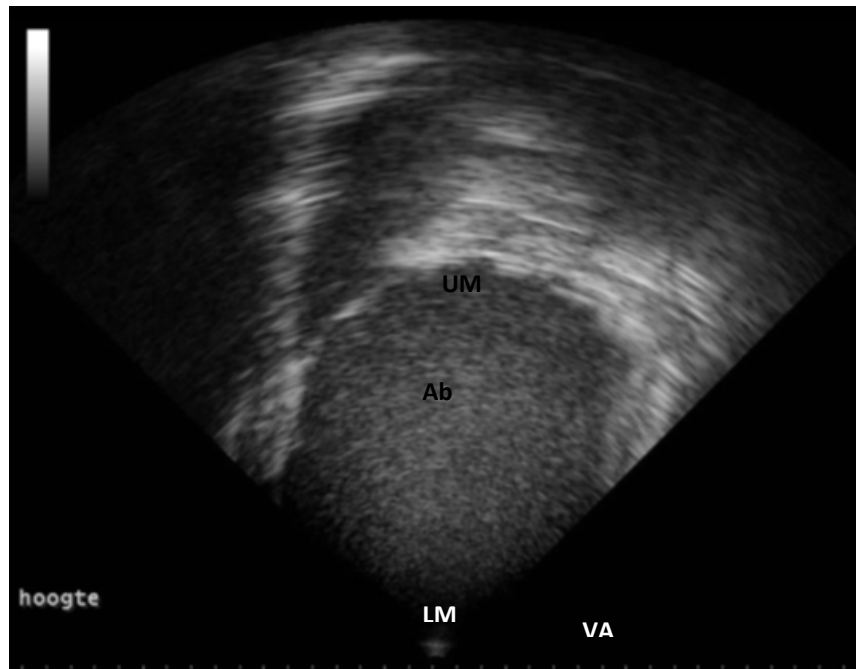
Ultrasonographic image of abomasum, preset: Canine A PA230, Depth: 27 cm. Ventral measurement of abomasal height. Ab: abomasum, LM: lower margin abomasal height, UM: upper margin abomasal height, VA: ventral abdominal wall.
